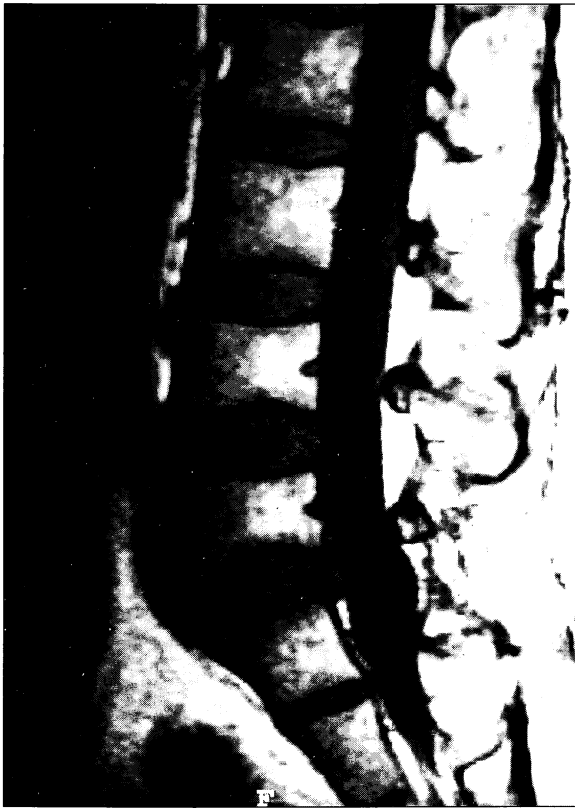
Sagittal T1-weighted image demonstrating a lesion in contiguity with the L5/S1 disc causing slight displacement of the thecal sac
